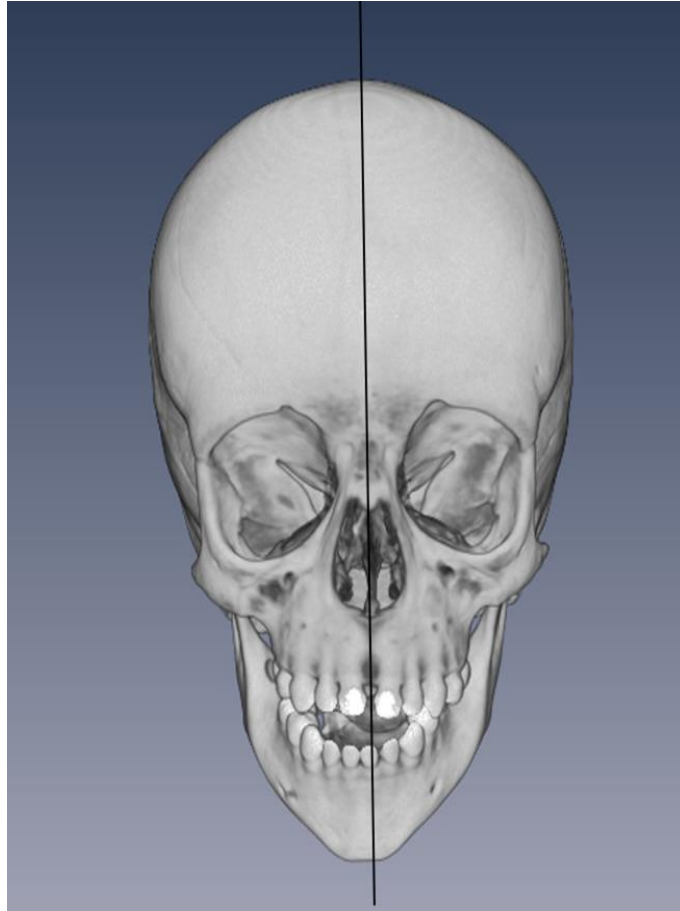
Image showing the 3D mesh rendering of a CT-scan of an infant (soft tissues temporarily removed) oriented along an imaginary midsagittal vertical plane. Image produced using Avizo 9.0. Courtesy of Dr Barraclough.
